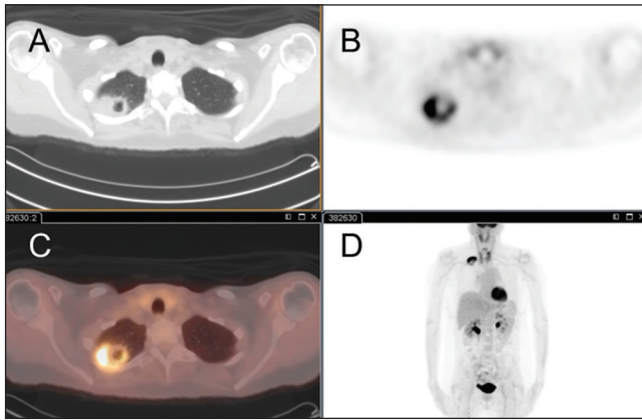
Cavitary non-small cell lung cancer. Fluorodeoxyglucose positron emission tomography-computed tomography, axial computed tomography (a), positron emission tomography (b), fused positron emission tomography-computed tomography (c), and maximum intensity projection image (d) of a 72-year-old woman with a history of squamous cell carcinoma of the right lung apex. The lesion measured 3.4 cm × 2.6 cm with a cavity of 1.5 cm, standardized uptake value of 10.9 and standardized uptake value ratio of 4.5. There was no positron emission tomography-computed tomography evidence of regional nodal or distant metastasis. The patient underwent right upper lobectomy that showed tumor invasion of the chest wall and the second rib, and the biopsy of peribronchial and hilar nodes were negative for malignancy, T4N0M0, Stage III. Chemotherapy had been planned, but she died 3 months after initial diagnosis
